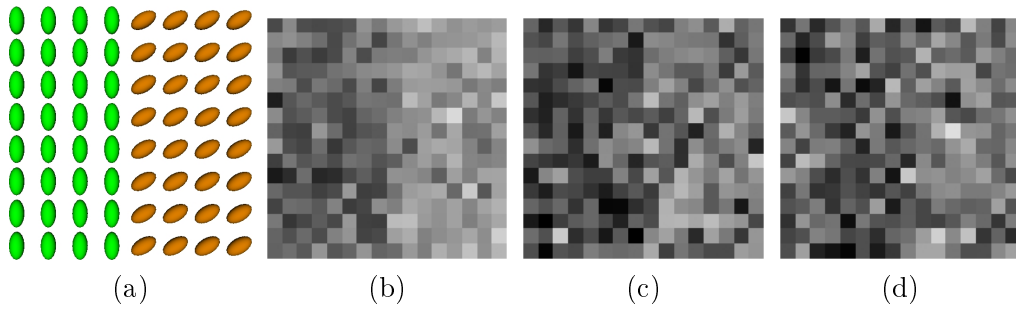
A slice of a generated DWI with $\sigma_n = 0.5$ (b), $\sigma_n = 1.0$ (c), $\sigma_n = 1.5$ (d). The encoding gradient is $\mathbf{g} = (-1, 1, 0)^\top$.
